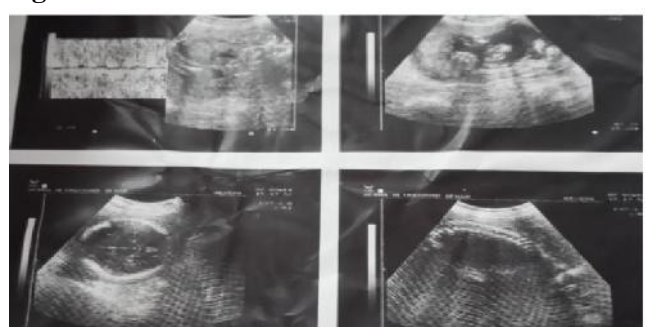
Ultrasound after rupture
